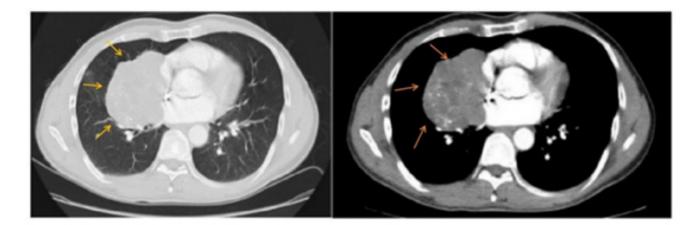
The thoracic-computed tomography (CT) scan revealed a  $9 \times 7.5$  cm hypodense lesion that extended from the perihilar segment to the medial segment of the right middle lobe of the lung (arrows).
